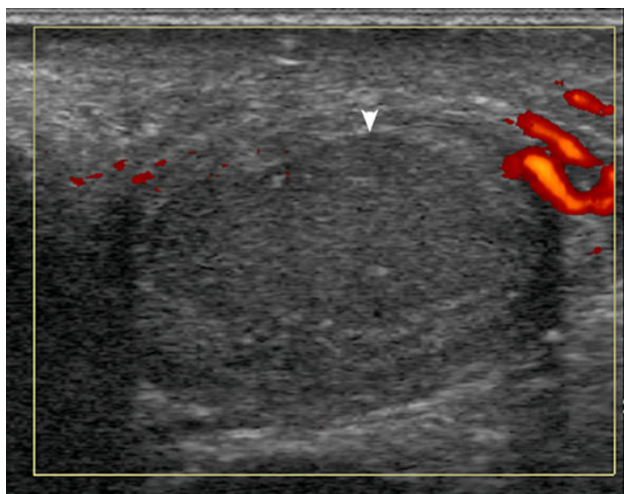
Testicular infarction due to torsion. Longitudinal US image in an 18-year-old presenting with pain approximately 30 h after onset of symptoms. Despite use of power Doppler and technique optimization, there is no flow in the testis. The testis is hypoechoic centrally (arrowhead) consistent with infarction. Orchiectomy yielded an infarcted testis
